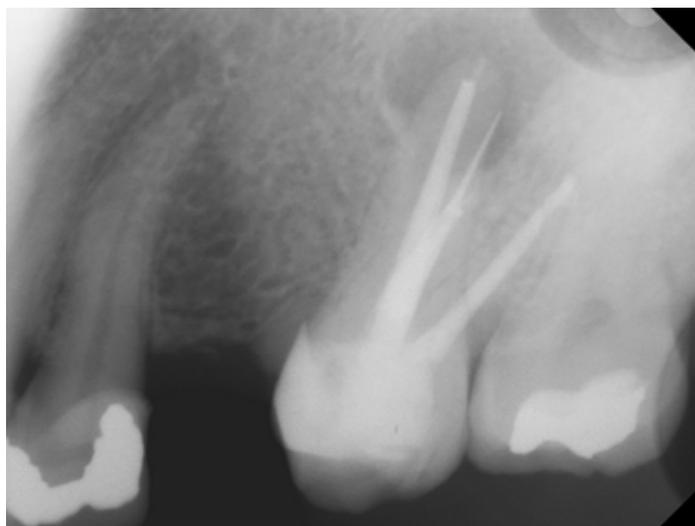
Periapical radiograph of tooth UL6 following obturation of all the canals. Note the fractured instrument in the mesiobuccal root extending beyond the apex.
